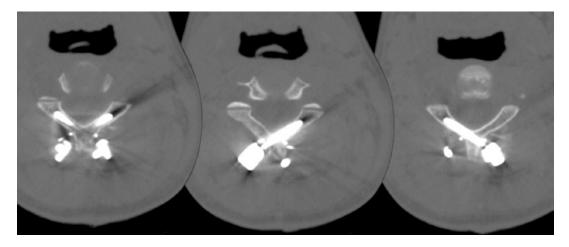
Postoperative CT scan of translaminar screw at C2. The entry point of a translaminar screw is usually at the junction between the spinous process and the contralateral lamina (*right*)
